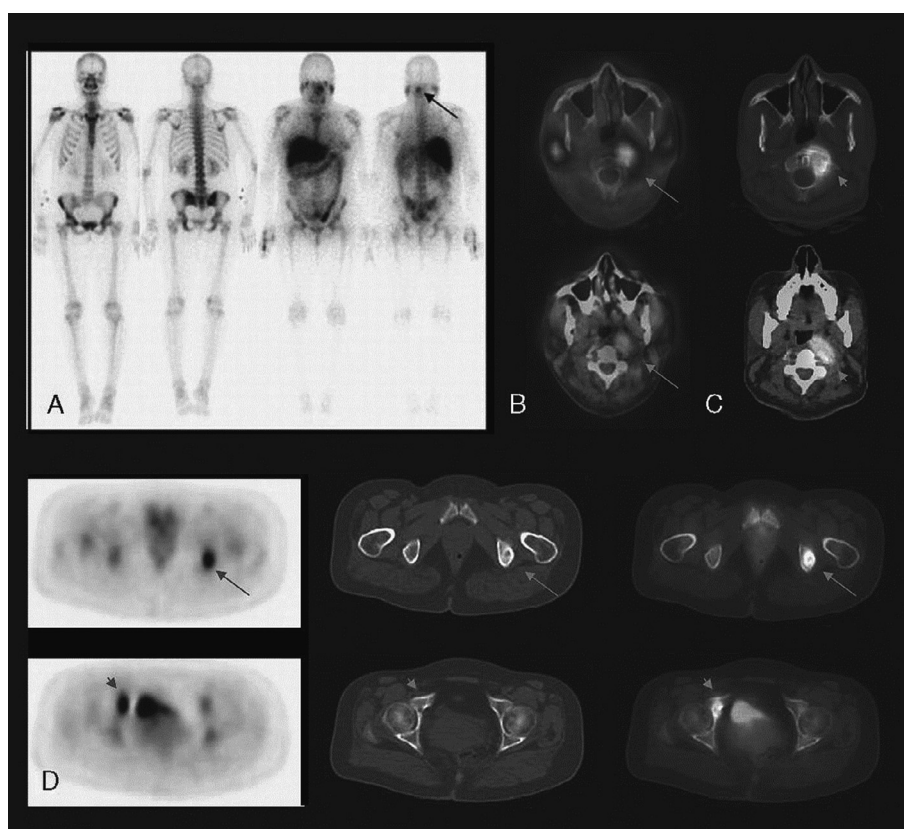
Set of images in study for diagnosis of Spondylodiskitis in C1 and C2 where planar images are indicated (A) and SPECT/CT ^{67}Ga scan images are indicated as (B) and PET/CT as (C) and (D) shows the adjacent soft tissue, which was diagnosed as infection of *M. tuberculosis* (Fuster et al., 2012).
